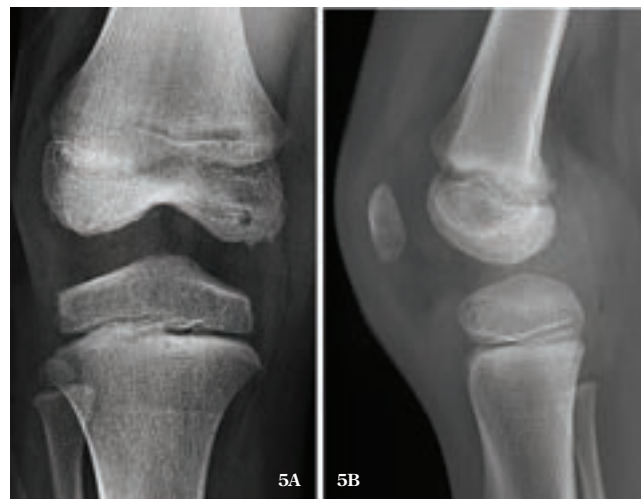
to 5B. The final anteroposterior (5A) and lateral (5B) radiographs showed no physeal arrest or angular deformity.
